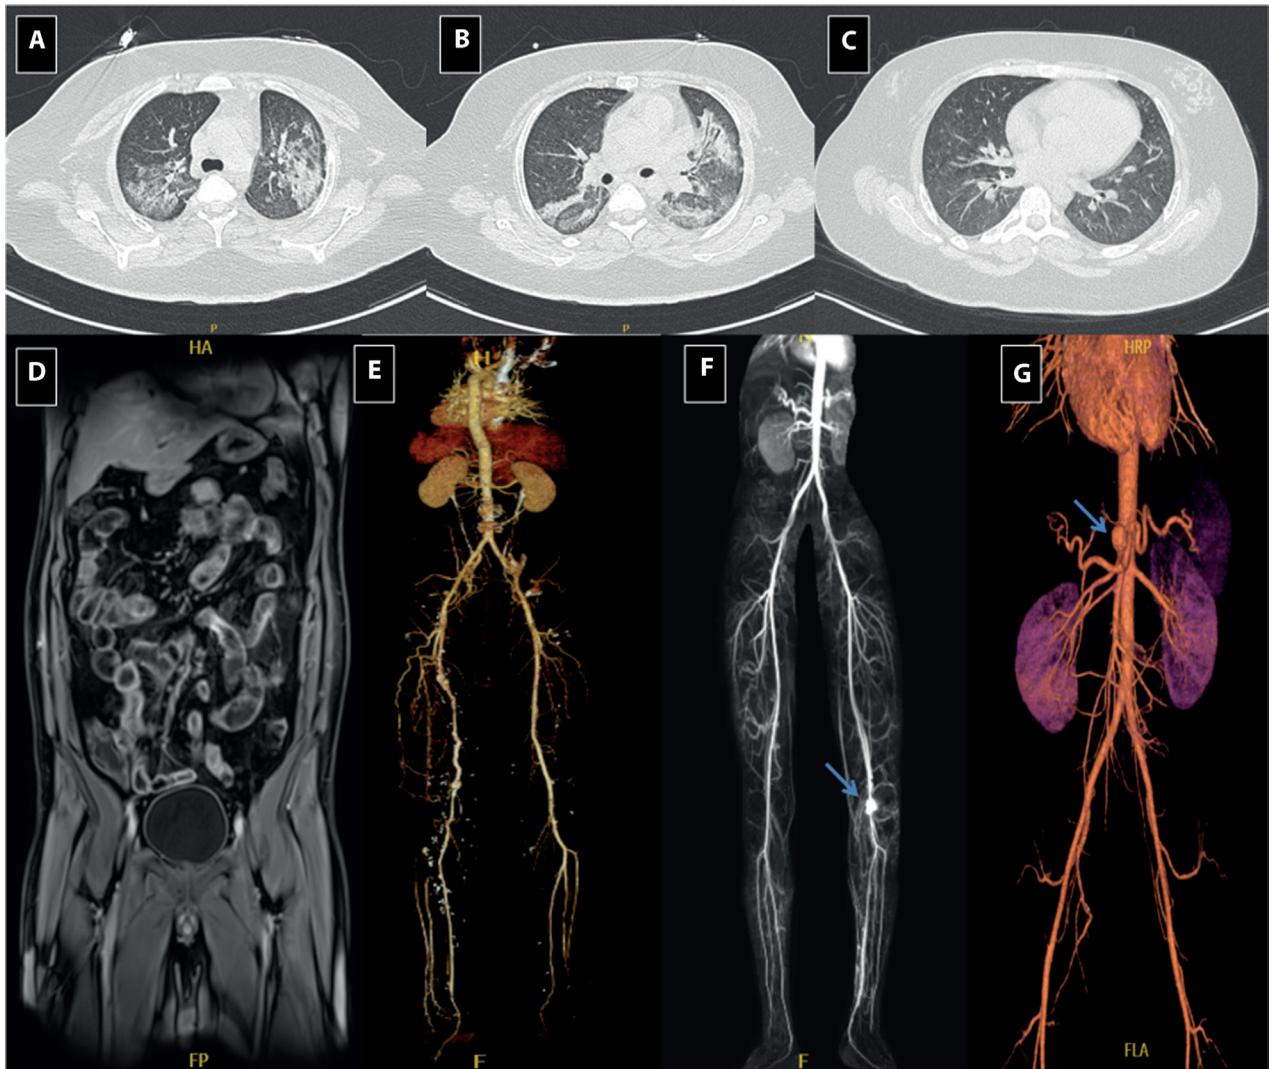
Miscellaneous findings: (A), (B) and (C): Axial lung window CT sequential images of the same patient, showing bilateral patchy autoimmune pneumonitis of different ages and (C): showing radiological improvement after initiation of immunosuppressive treatment; (D): Coronal reformatted CE CT of the abdomen and pelvis, showing a small intestinal BD enteritis; (E): 3D, MIP CTA of the abdominal aorta and lower limb arteries, demonstrating a beaded appearance of the LL arteries secondary to peripheral arterial vasculitis. (F): 3D, MIP CTA of the abdominal aorta and lower limb arteries, demonstrating a left popliteal artery aneurysm (Blue arrow); (G): 3D, MIP CTA of the abdominal aorta and lower limb arteries, demonstrating a celiac artery aneurysm (Blue arrow).
